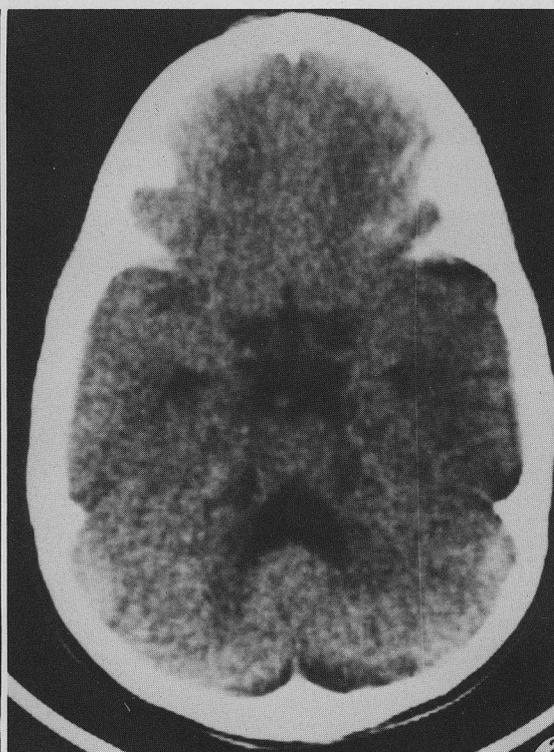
Enlarged fourth ventricle, vermian hypoplasia. CT, axial section, case 2.
